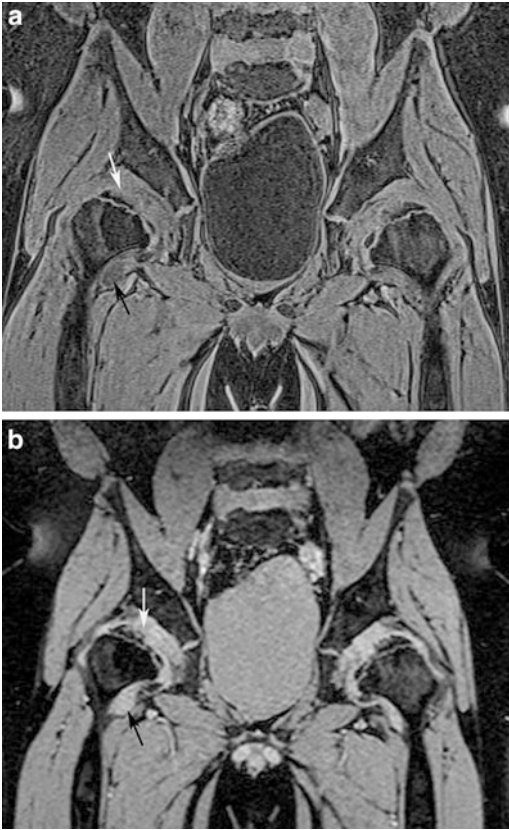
MRI of the pelvis without contrast on a 1.5 T magnet for a 12-year-old boy with multiple epiphyseal dysplasia. (a) Coronal 3D SPGR sequence (TR 7.5, TE 2.9, FA 13) demonstrated excellent spatial resolution, though there is little contrast between the signal intensity of the femoral head cartilage (*white arrow*) and adjacent muscle. Joint fluid was dark (*black arrow*). (b) Coronal 3D MEDIC sequence (TR 32, TE 14, FA 8) demonstrates bright signal from cartilage (*white arrow*) and fluid (*black arrow*) which are now brighter than adjacent muscle
